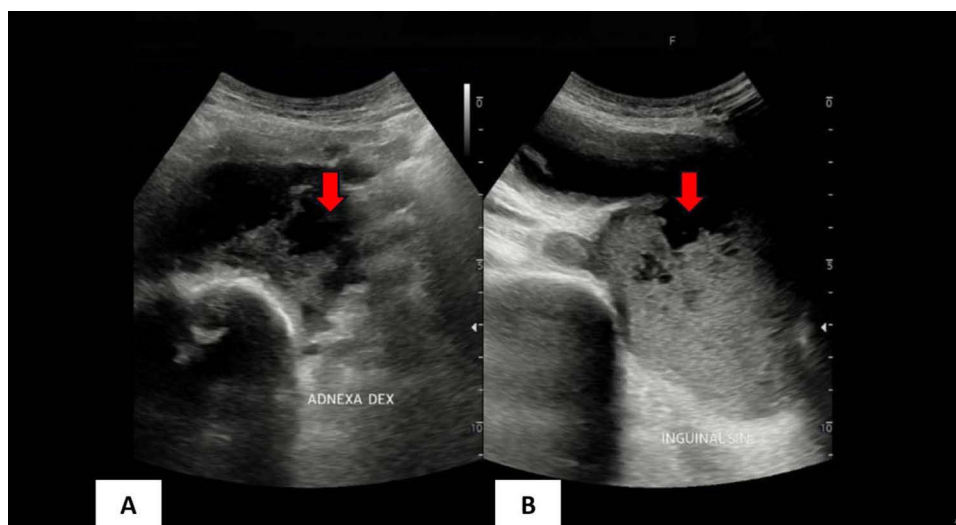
Abdominal Ultrasound. An abdominal Ultrasound conducted on October 31, 2025, shows two cystic lesions with internal debris and iso-to-hypoechoic characteristics (red arrows). (A) The lesions measured approximately $4.9 \times 4.9 \times 6.6$ cm with an estimated volume of 43.7 mL on the right side, while (B) Those on the left side measured $5.2 \times 5.2 \times 6.7$ cm, corresponding to an estimated volume of 50.2 mL. No hepatic, splenic, or renal abnormalities were observed.
